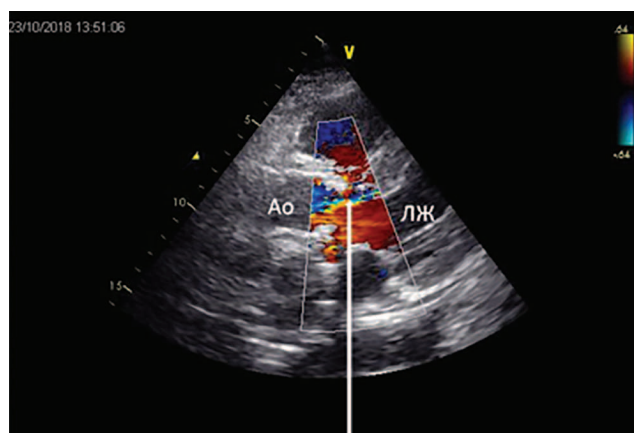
Transesophageal Doppler echocardiography of patient P. LV – left ventricle. Ao – aorta. Color Doppler imaging determines blood flow in the zone of conduit detachment from the fibrous ring (arrow).
